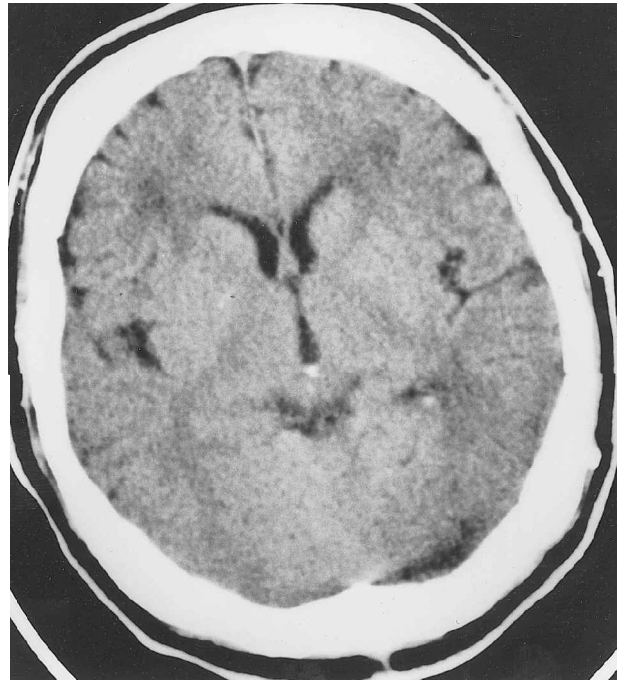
Plain CT obtained during mute phase.
